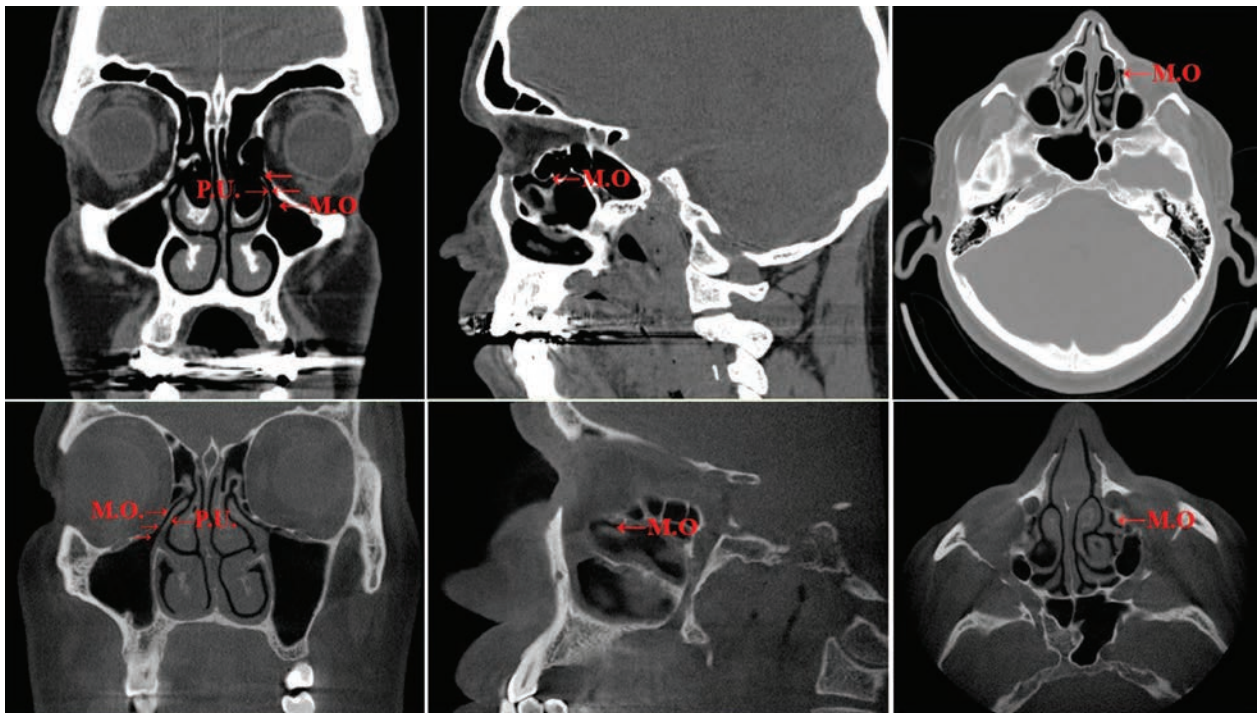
Coronal, sagittal and axial sections of standart-CT (up) and CBCT views of including Proc Uncinatus, Maxillary Ostium, Infundibulum
